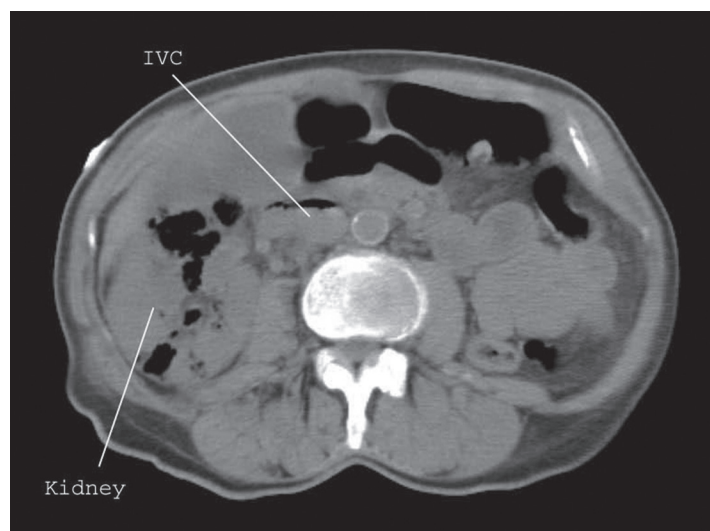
Abdomen computed tomography image without intravenous contrast showing right-sided emphysematous pyelonephritis with an air-fluid level in the inferior vena cava (IVC).
